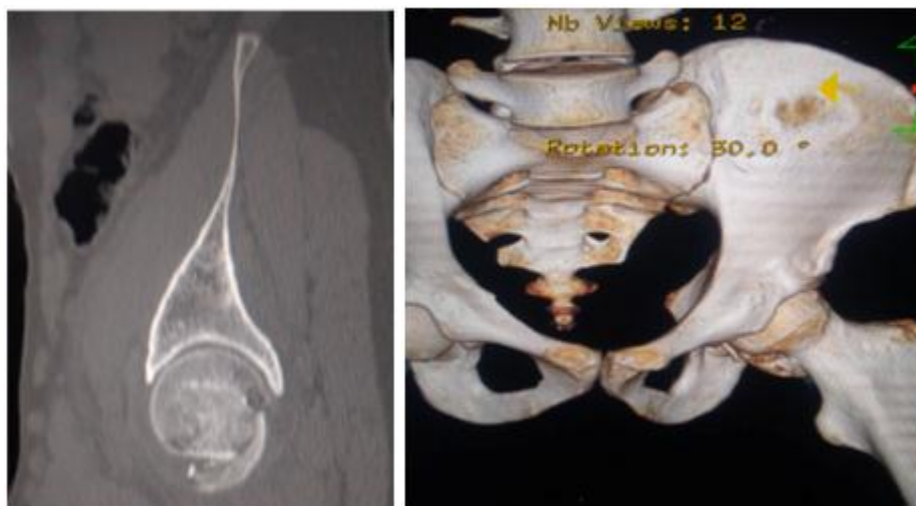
Pre-operative CT images showing Pipkin type 2 fracture head femur
